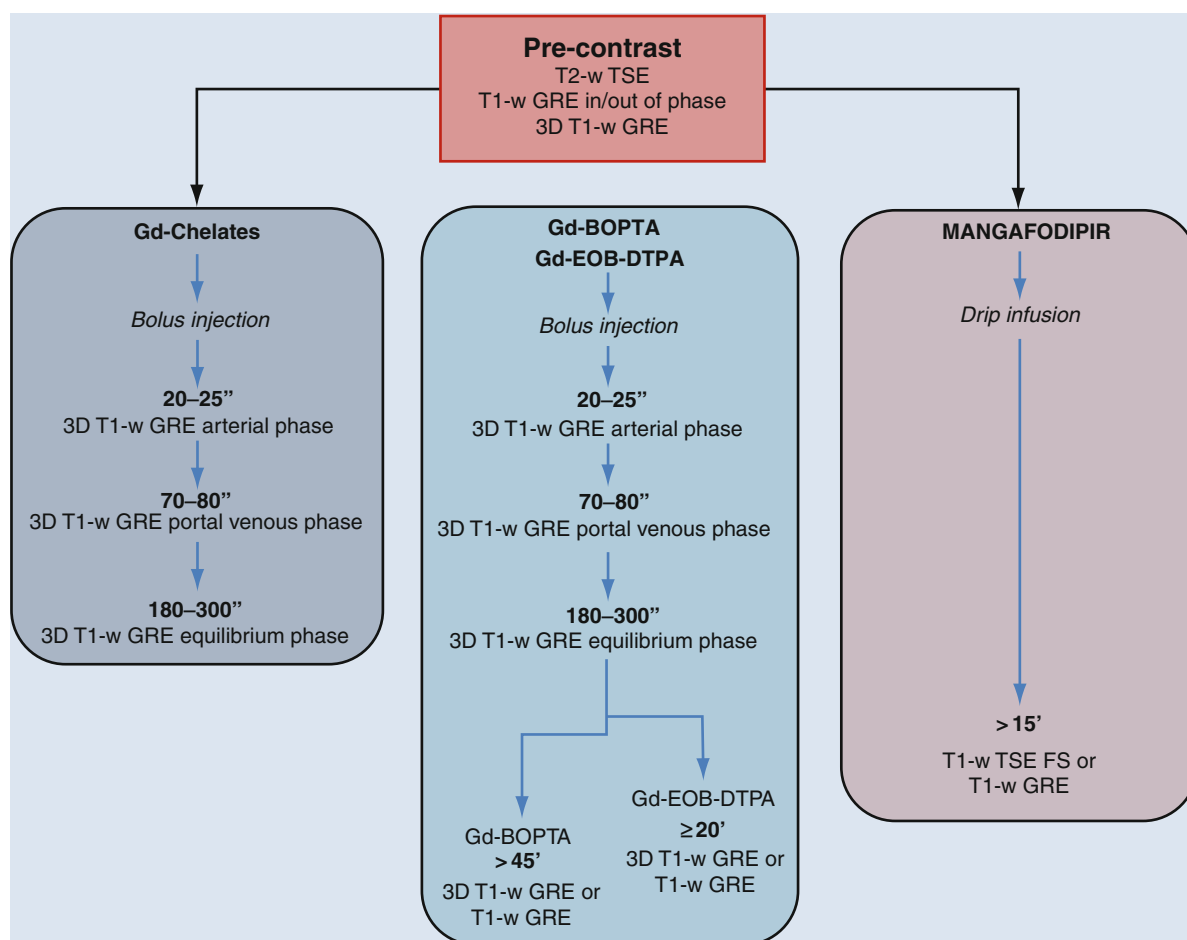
Imaging protocols for paramagnetic contrast-enhanced MRI
